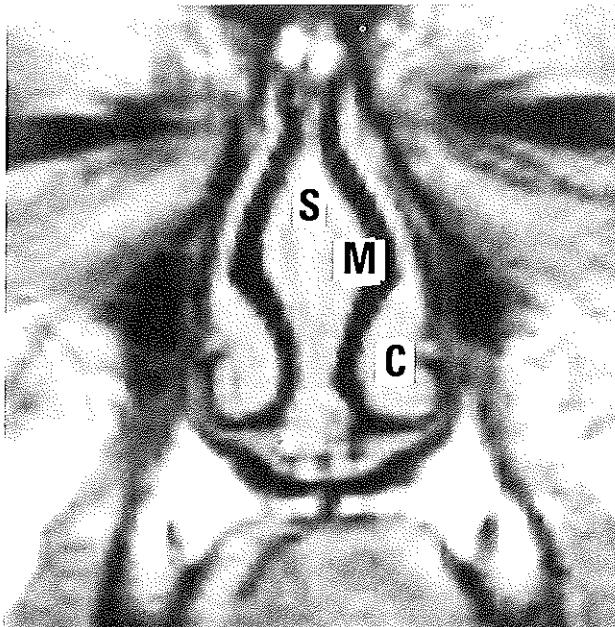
Coronal MRI of nasal septum; T2-weighted image of a 2-year-old patient. S: septal cartilage; M: septal mucosa; C: concha inferior.
